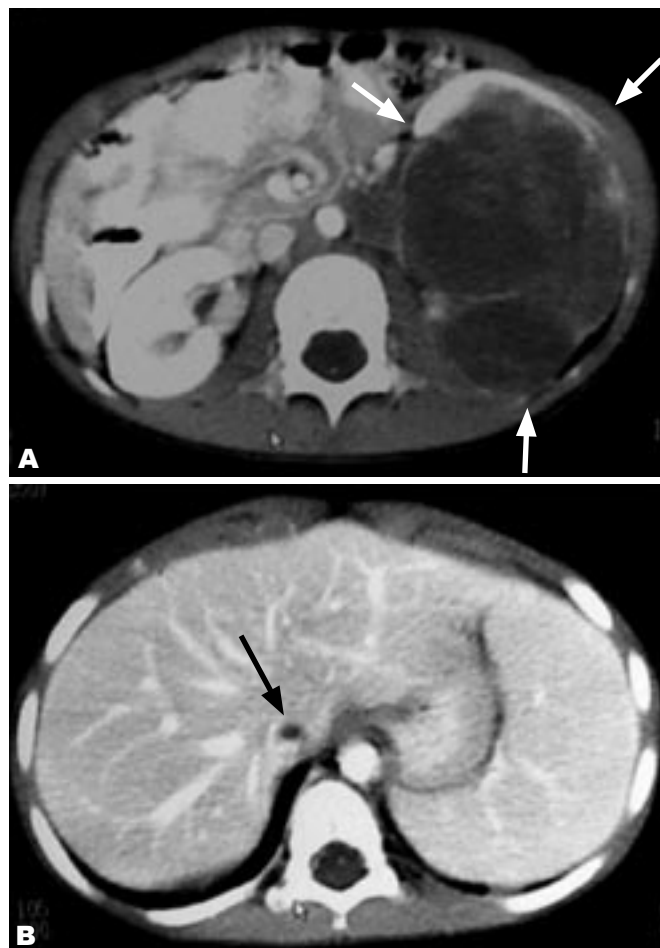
Axial CT image demonstrates:
